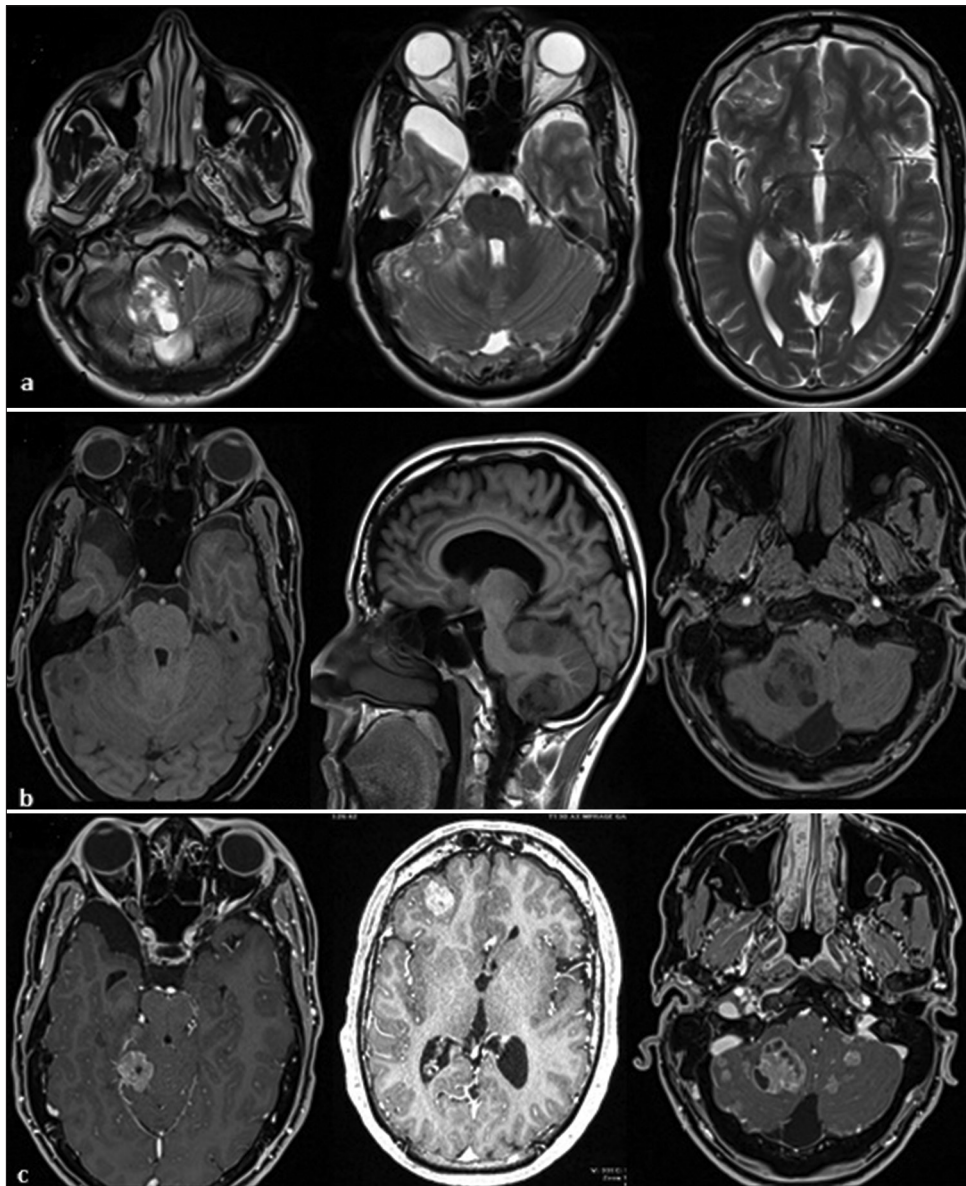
(a) T2-weighted images: mixed hyper-intensity/hypo-intensity signals. (b) T1-weighted images: Extra-axial and intra-axial masses with no spontaneous hyperintensity and large area hypointensity. (c) T1 W images after gadolinium injection: solid cystic component mass with significant enhancement.
